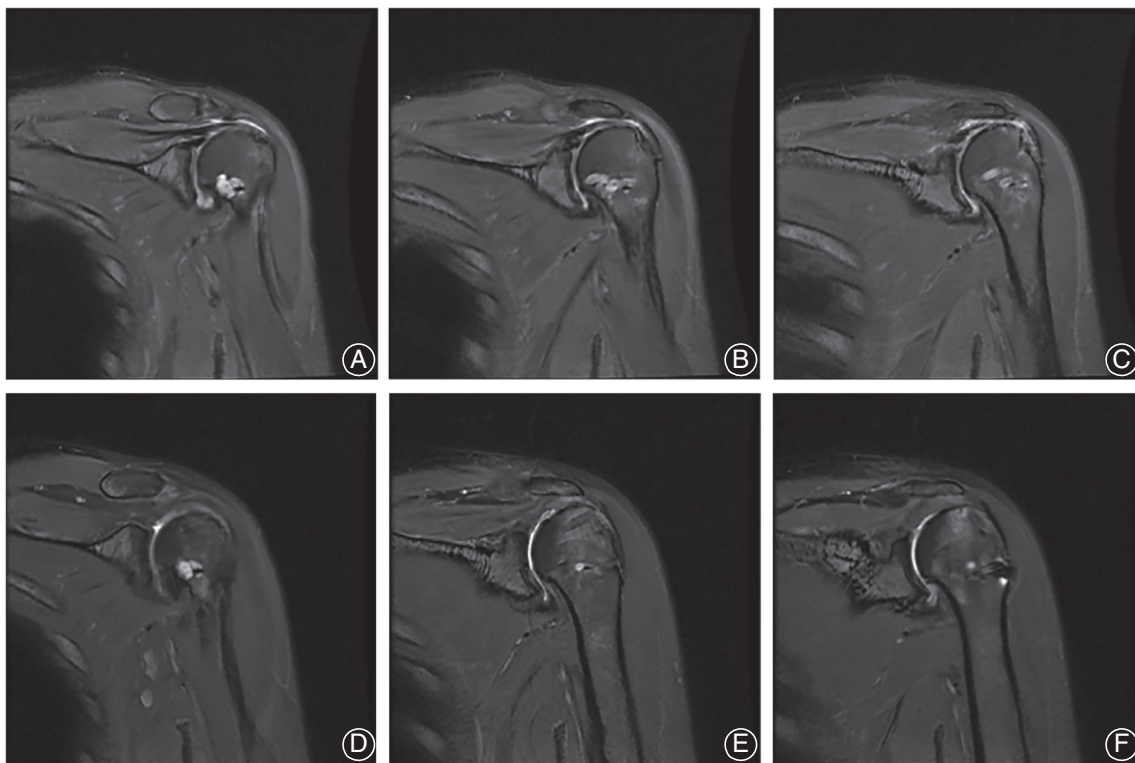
This patient underwent autologous ITB-GT interposition for IRCT (left shoulder). (A-C) The preoperative MRI showed a massive rotator cuff tear with a significantly narrowed AHI. (D-F) At final follow-up, the tendon integrity was fully intact and the AHI significantly improved to 9 mm.
